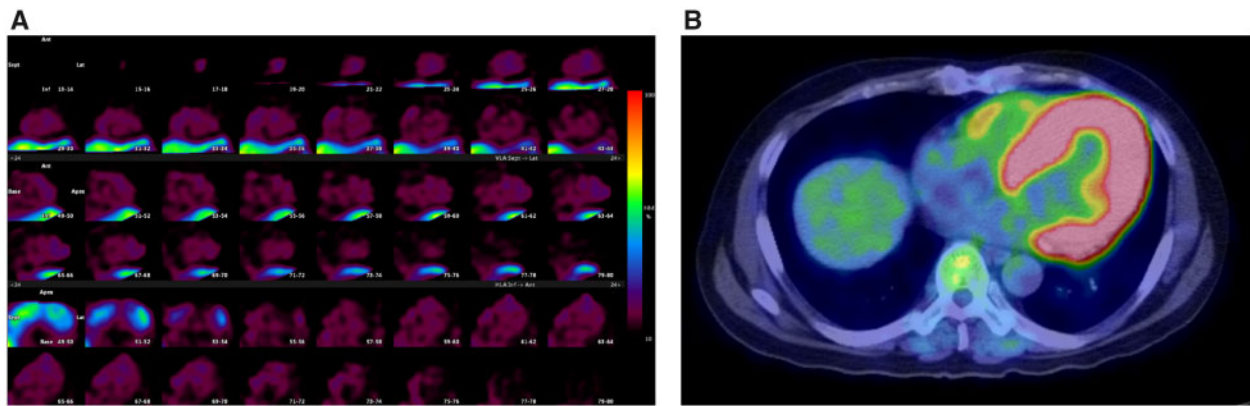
BMIPP scintigraphy and ^{18}F -fluorodeoxyglucose positron emission tomography. (A) Image obtained at rest, 30 min after BMIPP administration. The heart showed reduced BMIPP uptake. (B) An axial ^{18}F -fluorodeoxyglucose positron emission tomography image is shown. The heart showed increased ^{18}F -fluorodeoxyglucose uptake.
